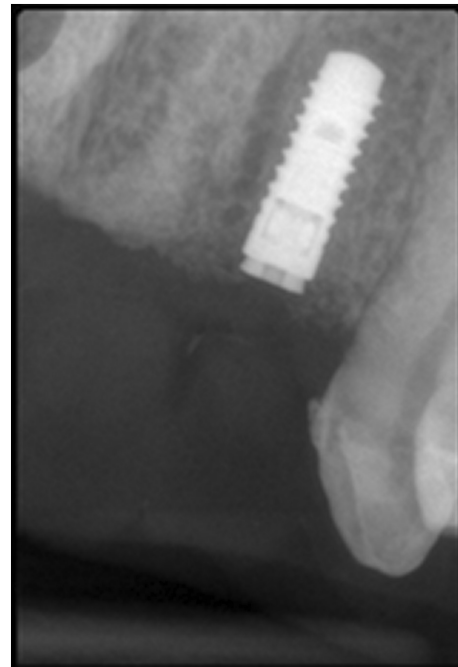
Periapical radiograph showing implant # 22.
